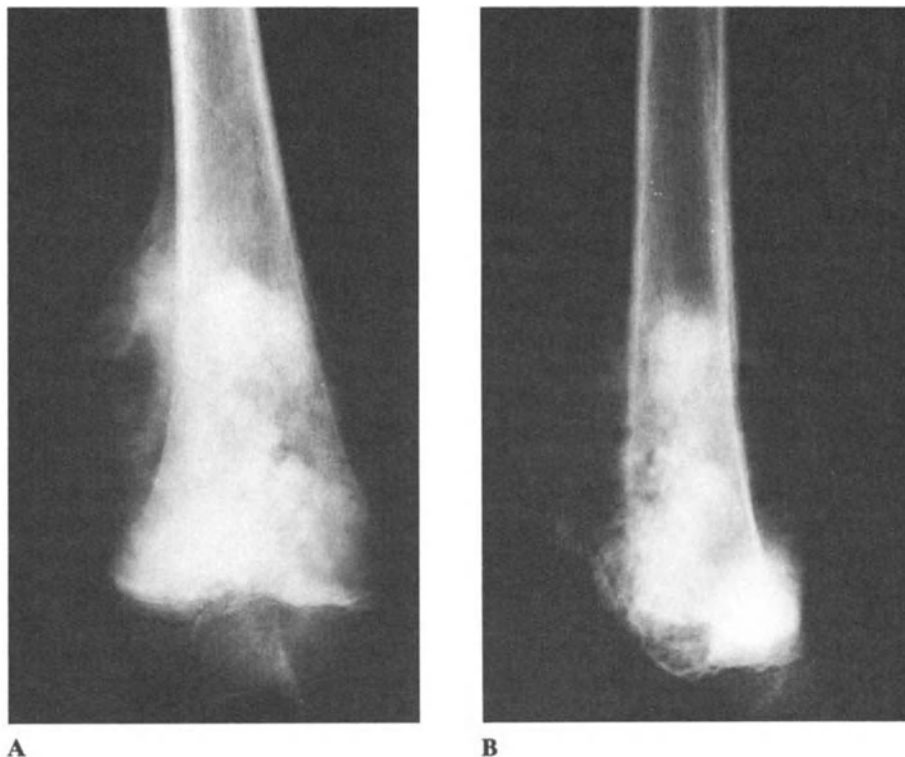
Osteoblastic osteosarcoma in a 7-year-old female. A, B: Standard x-rays of the distal femur showing the involvement of the growth plate.
